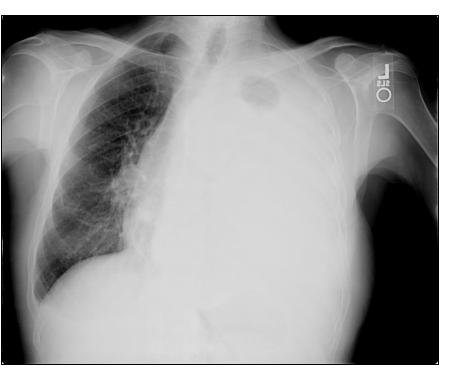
Chest x-ray revealing re-accumulation of pleural fluid within left lung.
